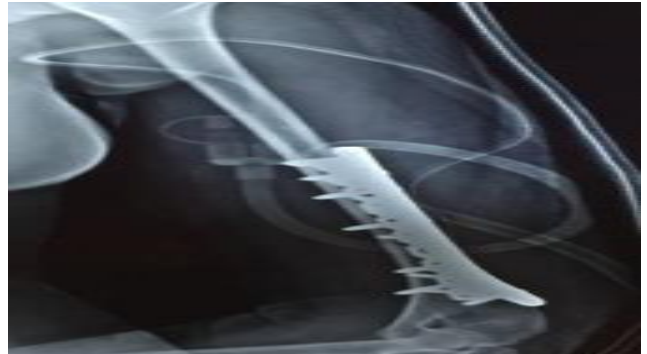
Post OP X-ray posterior approach.
